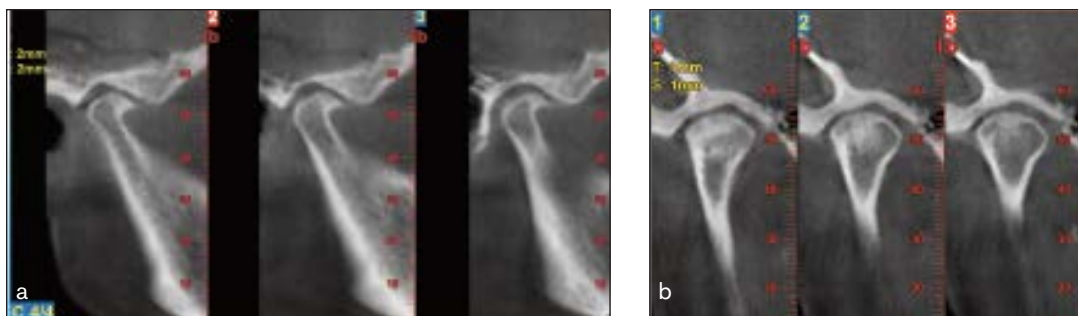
CBCT images of a TMJ of a patient with a RDC/TMD diagnosis of osteoarthritis and with osteoarthritic changes (erosions and osteophyte). (a) Sagittal. (b) Coronal.
